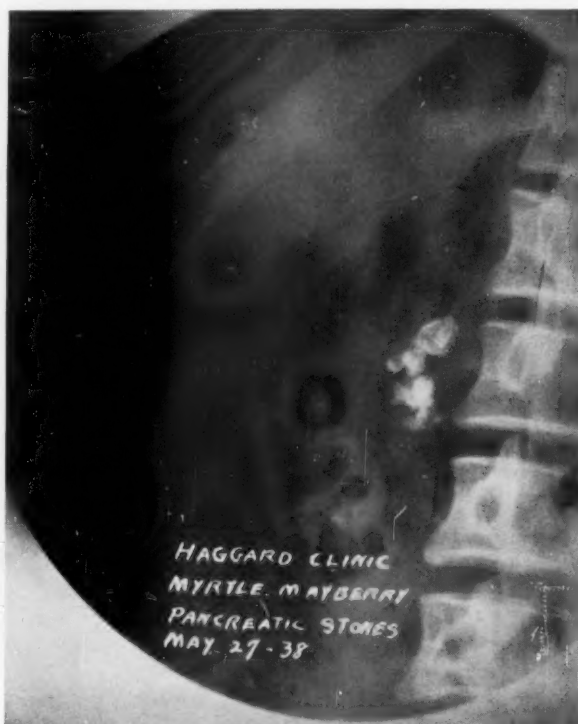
Author's case. Negative exploration elsewhere for gallstones. Roentgenogram afterwards showed pancreatic stones. Successful removal five weeks after exploration.
